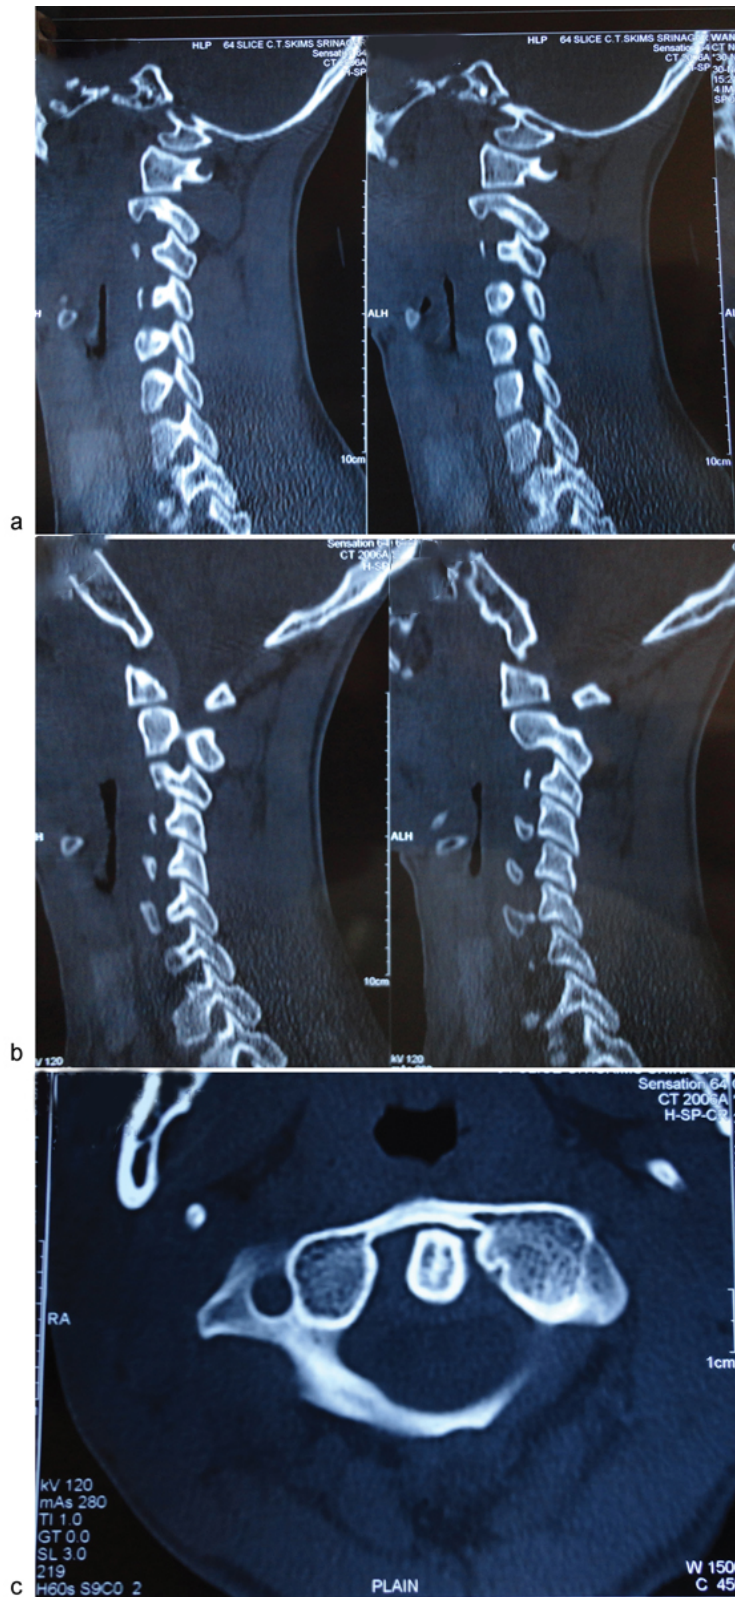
(a) Computed tomography (CT) of right facet showing posterior rotation of C1 on C2. (b) CT of left facet showing anterior rotation of C2 on C1. (c) Axial CT showing rotation of odontoid toward left lateral mass of C1.
